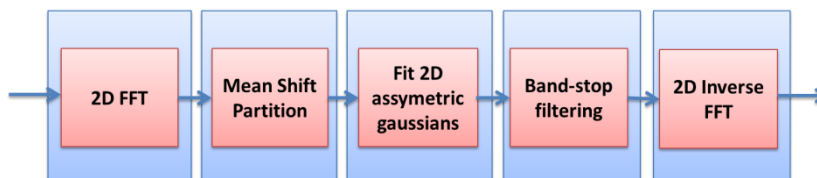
Block scheme for segmentation in t-MRI using the strategy proposed in [83].
